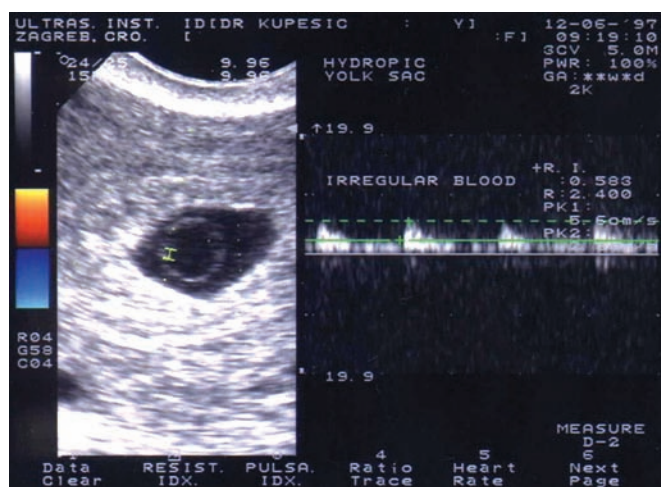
A transvaginal sonogram of a hydropic yolk sac at 6 weeks' pregnancy. Continuous diastolic flow is easily obtained from the hydropic yolk sac ($RI=0.58$). Patient aborted in 1 week and karyotyping of the residual products of conception revealed trisomy 21.
